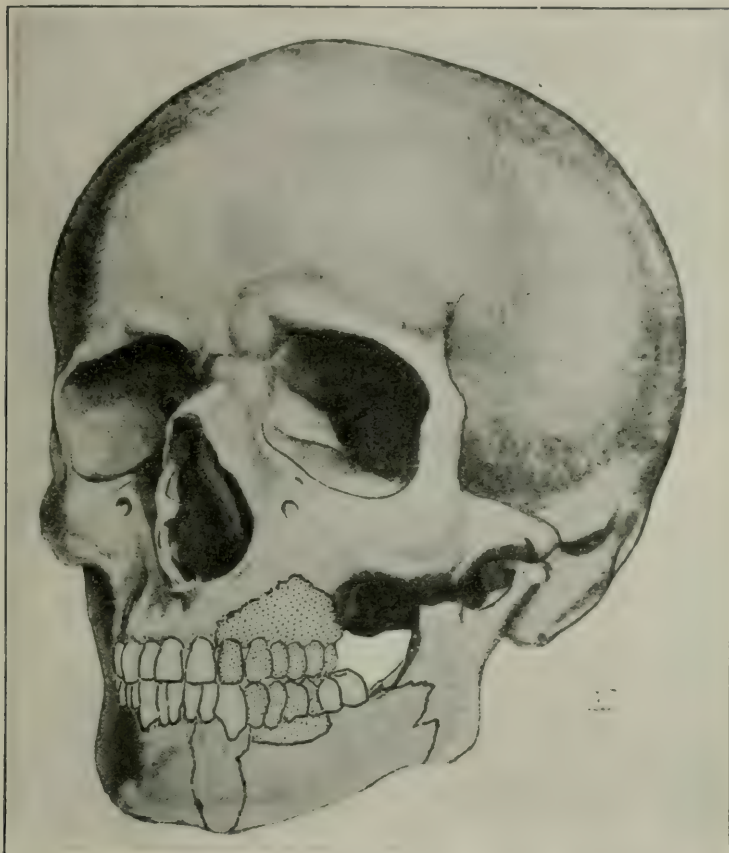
This figure shows the bony portions of the inferior maxillary destroyed by the projectile. They are indicated by a dotted area. This reproduction of an X-ray picture shows the lines of vertical fracture which occurred on the horizontal ramus of the lower jaw, one at the junction with the ascending ramus and the other a little external to the symphysis menti.
